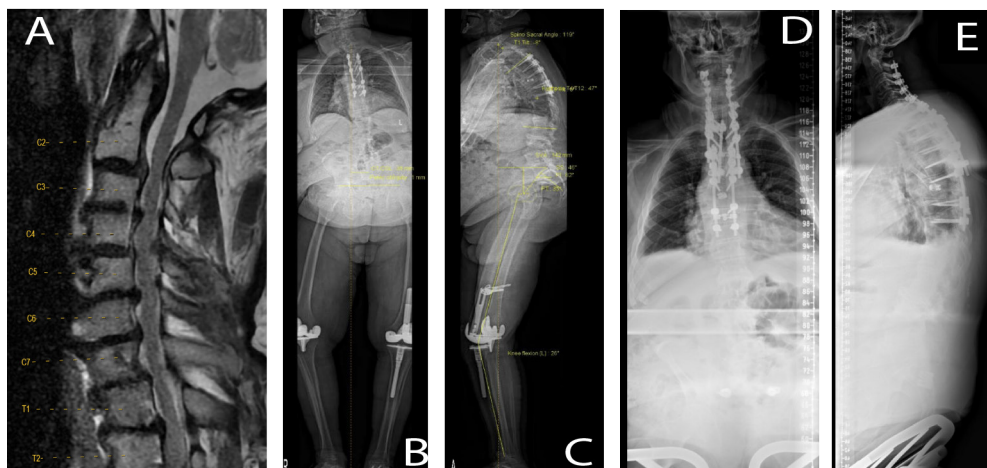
Sixty-eight-year-old man who underwent posterior C2–T6 fusions extension into prior fusion construct and C2–T2 laminectomy for progressive cervical myelopathy status post prior T7 corpectomy and T4–T9 fusion following T6–T7 pathologic fracture secondary to osteomyelitis. (A) Preoperative magnetic resonance imaging demonstrating severe stenosis from C2 to T2. (B) Preoperative anteroposterior (AP) and (C) lateral EOS scans demonstrating prior posterior hardware. (D) Postoperative AP and (E) lateral stitched scoliosis films highlighting a titanium rod construct spanning C2–T9.
